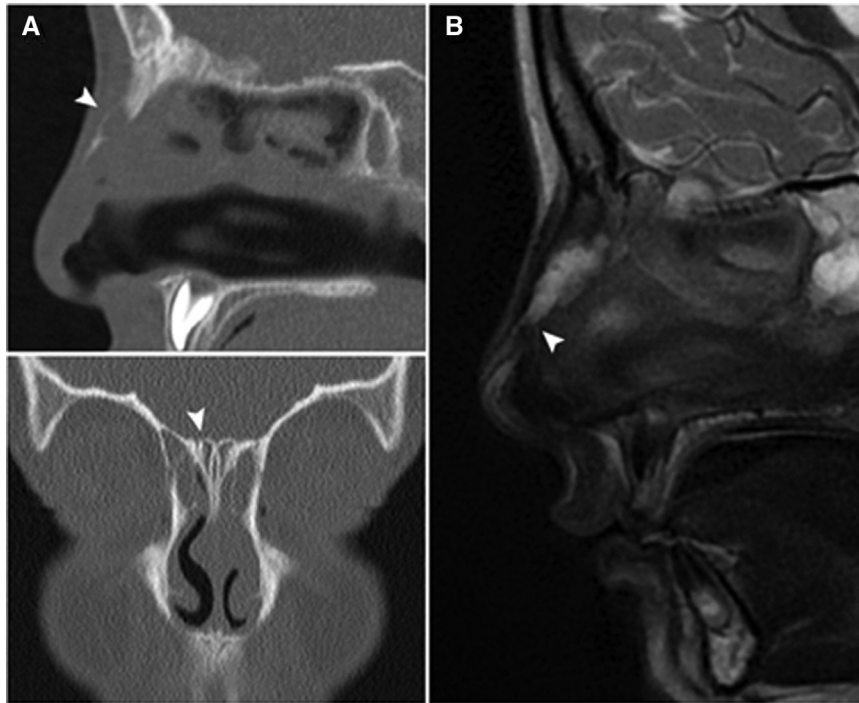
Imaging rules out intracranial extension of the dermoid and is essential for differential diagnosis. A, Computed tomography scan in sagittal view (up), showing a large defect in the right nasal bone (*arrow*) and no communication between the nasal space and anterior cranial fossa, and coronal view (down) showing a bifid and pneumatized crista galli (*arrow*). Frontal sinus aplasia is noticeable. B, Sagittal magnetic resonance imaging showing the course of the nasal dermoid fistula from the prenasal space to the nasal tip (*arrow*).
